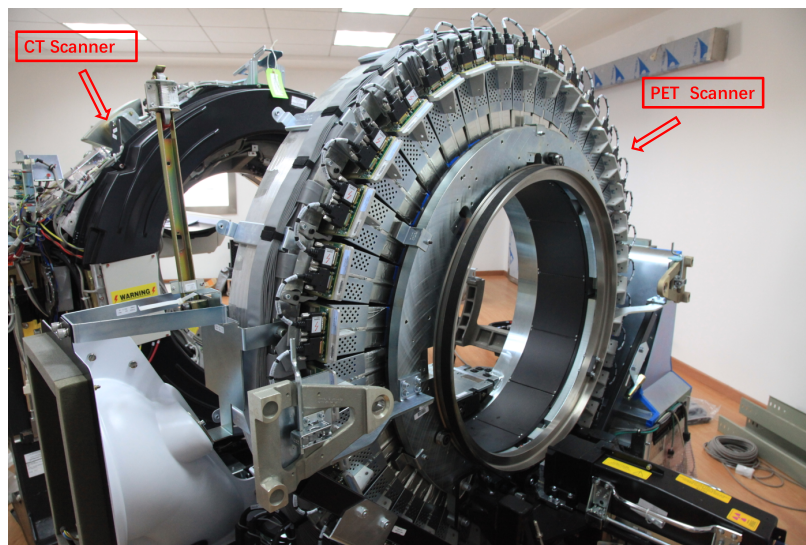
Photo of the internal scanning ring of a certain brand PET/CT in clinical practice
